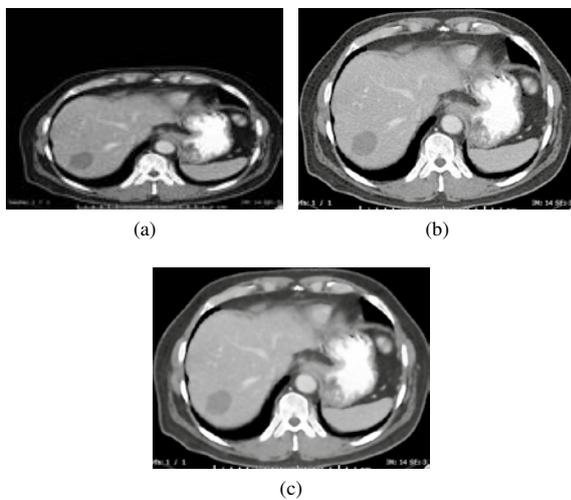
(a) Original CT image (b) The cropped image (c) The cropped and smoothed image
